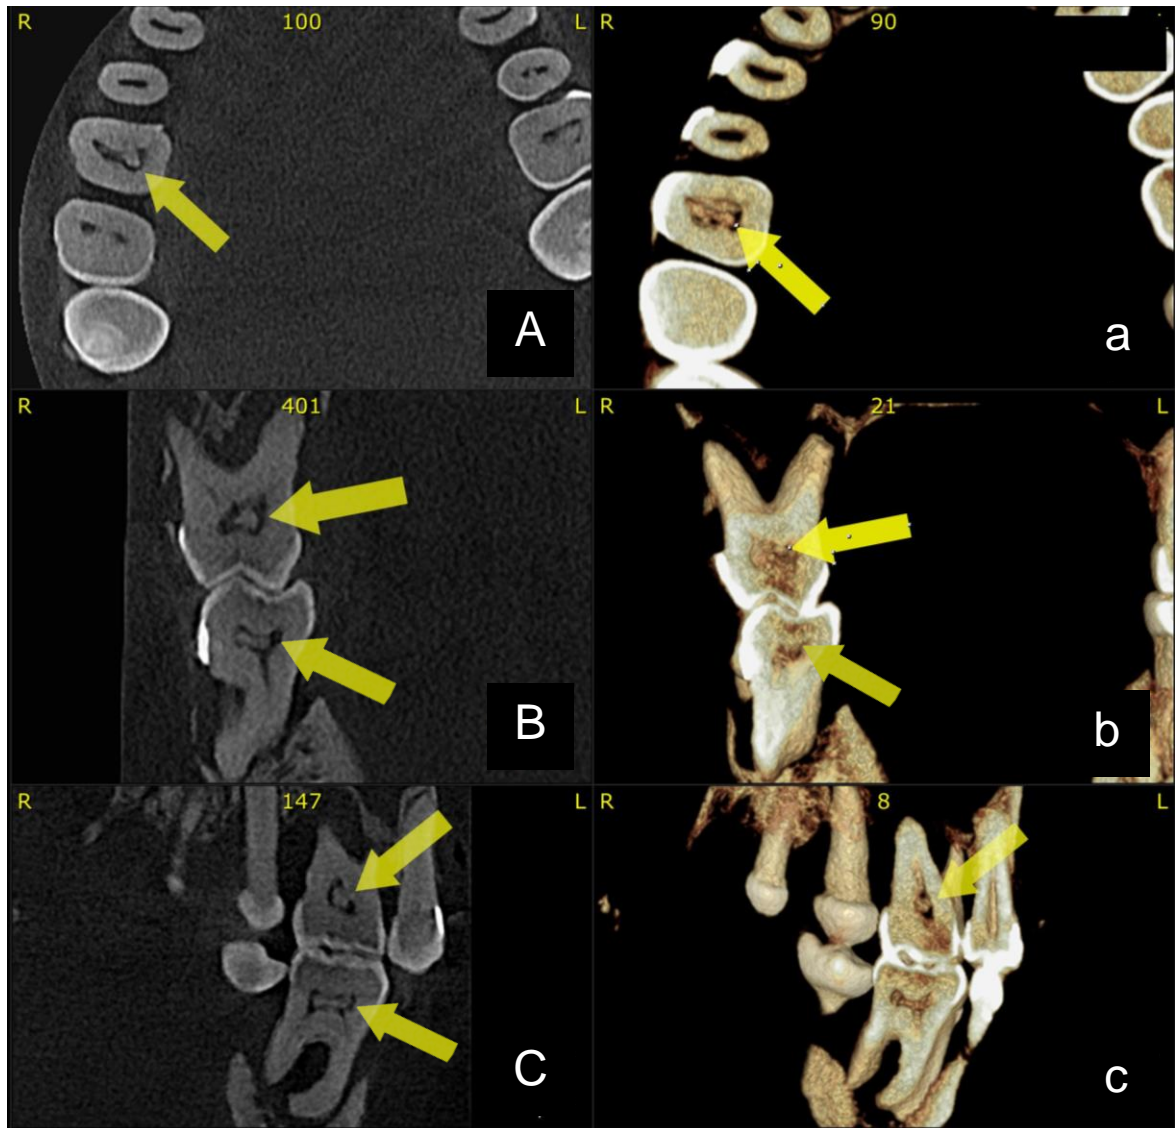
Presence of pulp stone in first superior right molar (yellow arrow) and in first lower right molar, on axial (A), sagittal (B) and coronal (C) planes, by 3D CBCT reconstruction.
